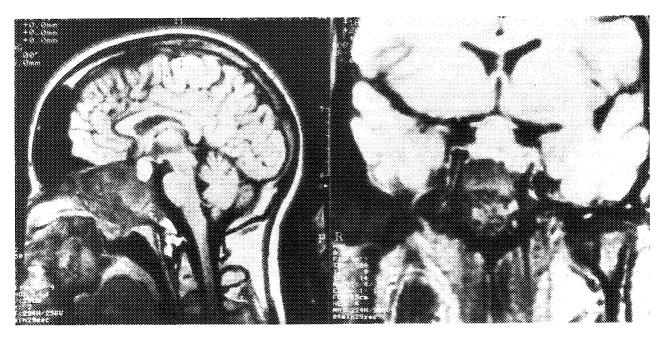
Cranial magnetic resonance imaging showing an extensive bone fibrous dysplasia and a pituitary macroadenoma in a 23-year-old woman with McCune-Albright syndrome and acromegaly.
